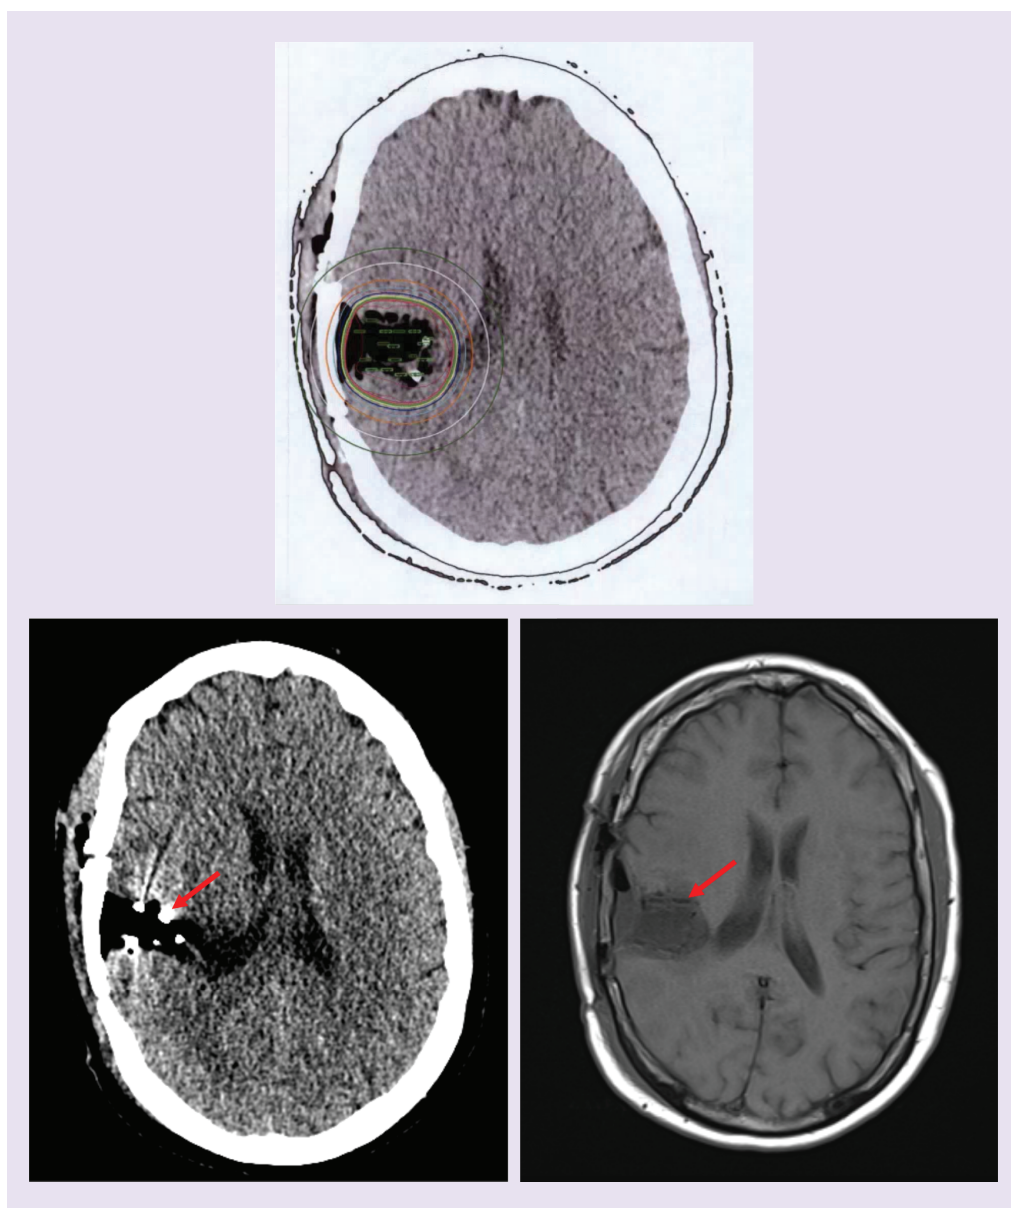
Head CT scan showing radiation dosage plan (top), computed tomography (bottom, left) and MRI (bottom, right) showing GammaTiles® placed after tumor resection. Arrows indicate the encapsulated ¹³¹I Cs seeds (left) and GT (right).
